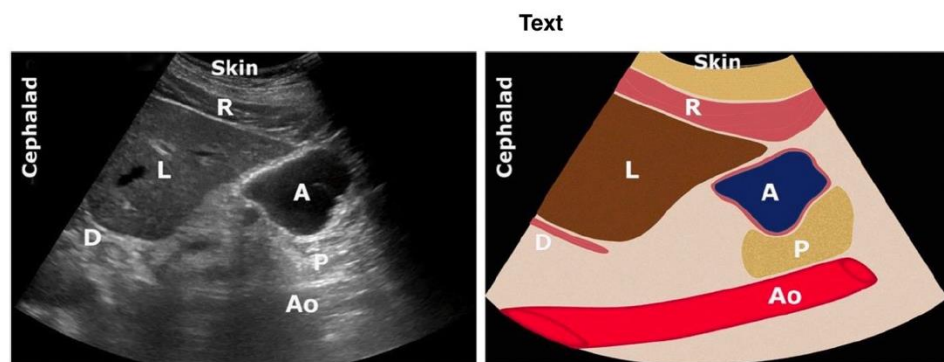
Ultrasound image showing clear fluid gastric contents. R – Rectus abdominis muscle, A – antrum, Ao- Aorta, L – Liver, P – pancreas, L – liver
